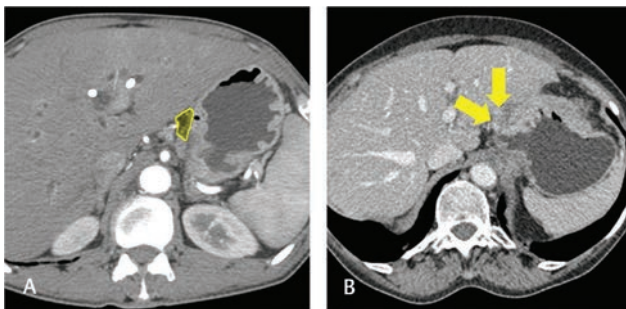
Station 3. Axial computed tomography images in arterial (A) and venous (B) phase. Station 3 location (yellow area) is depicted in figure (A) along the left gastric artery branches and distal part of right gastric artery and its second branch, along the lesser curvature of stomach. Figure (B) shows few lesser curvature nodes (arrows). Gastric wall thickening can also be seen in (B).
